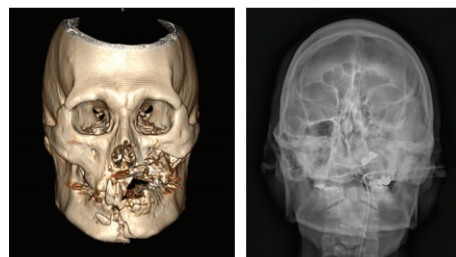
Three-dimensional CT and Skull x-ray photo showing panfacial fracture. Maxilla and mandibular teeth were missing.
